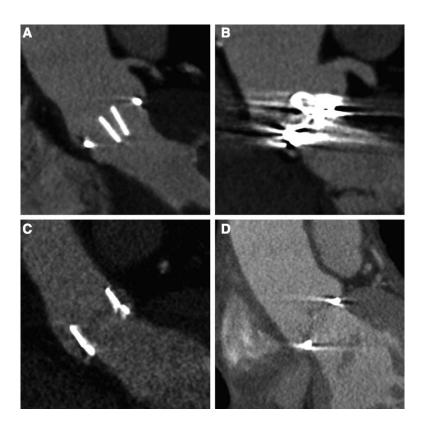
Prosthetic heart valve related artifacts on computed tomography. A, St. Jude bileaflet valve, (B) Björk-Shiley monoleaflet valve, (C) Perimount biological valve, and (D) mitroflow biological valve.
